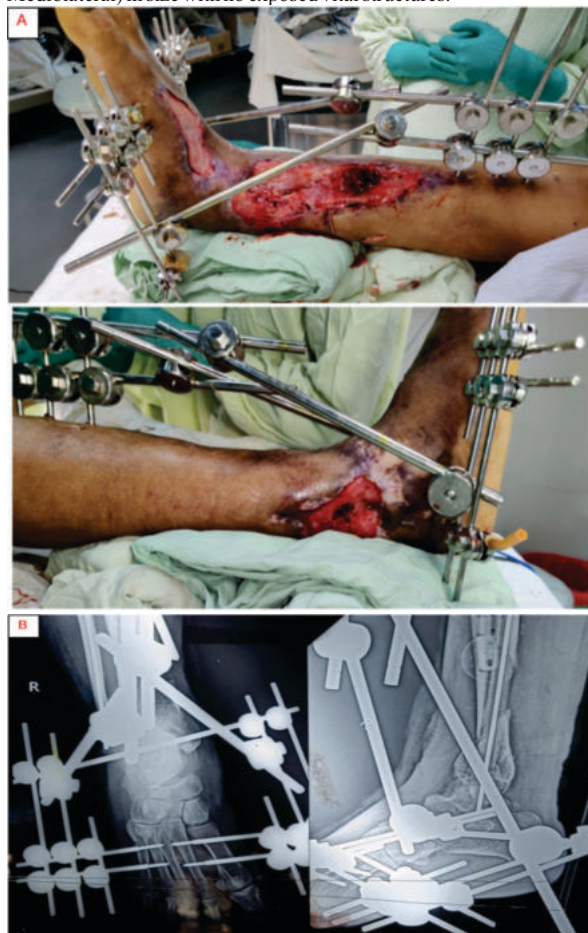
A. Photograph of the defect of right lower extremity, B. Antero-posterior & Lateral view radiograph of right lower extremity.
